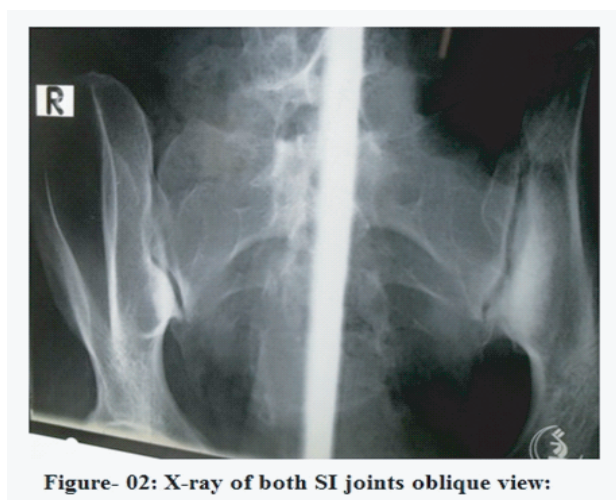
X-ray of both SI joints oblique view:
